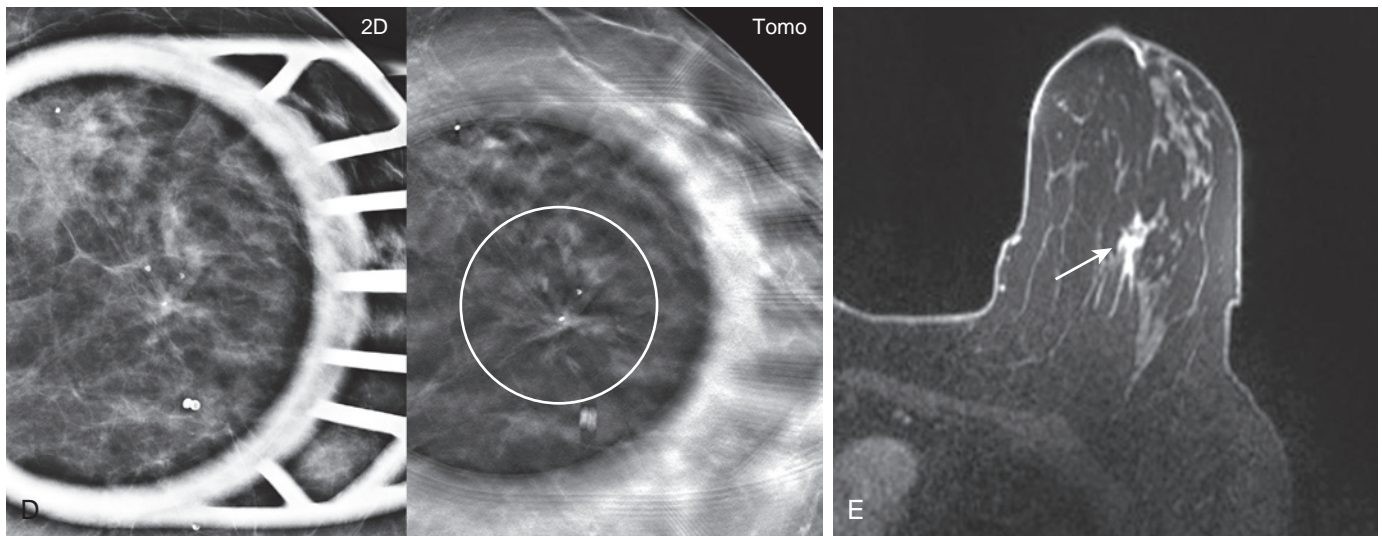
cont'd (D) Again, ultrasound was negative. (E) The patient underwent MRI that showed a corresponding focal enhancing area (*arrow*) with washout kinetics. MR biopsy was performed revealing moderately differentiated infiltrating ductal carcinoma, ER/PR+, Her2-.
